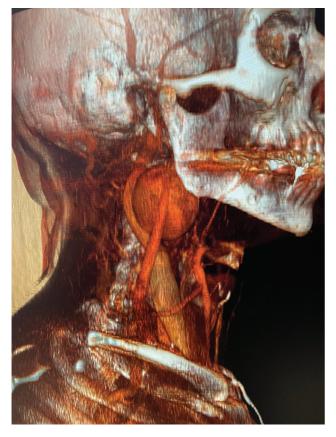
Computed tomography reconstruction of internal carotid artery aneurysm.
